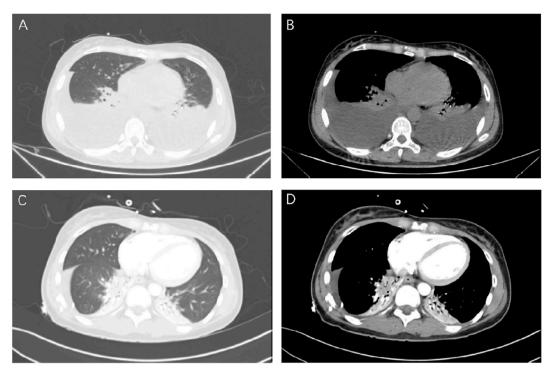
Chest CT images before and after treatment. On the 3rd day after surgery, chest CT of lung window (A) and mediastinal window (B) showed massive bilateral pleural effusions. On the 6th day after surgery, chest CT images of lung window (C) and mediastinal window (D) exhibited significantly reduced bilateral pleural effusion.
